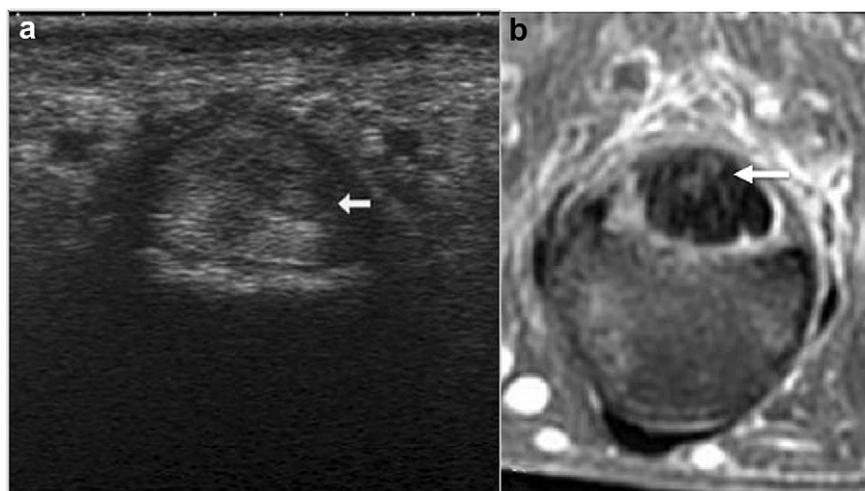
Tendinosis associated with trigger finger. The presence of an intratendinous nodules is manifested by a hypoechoic image on sonography (a) and hyperintensity on MRI (b).
